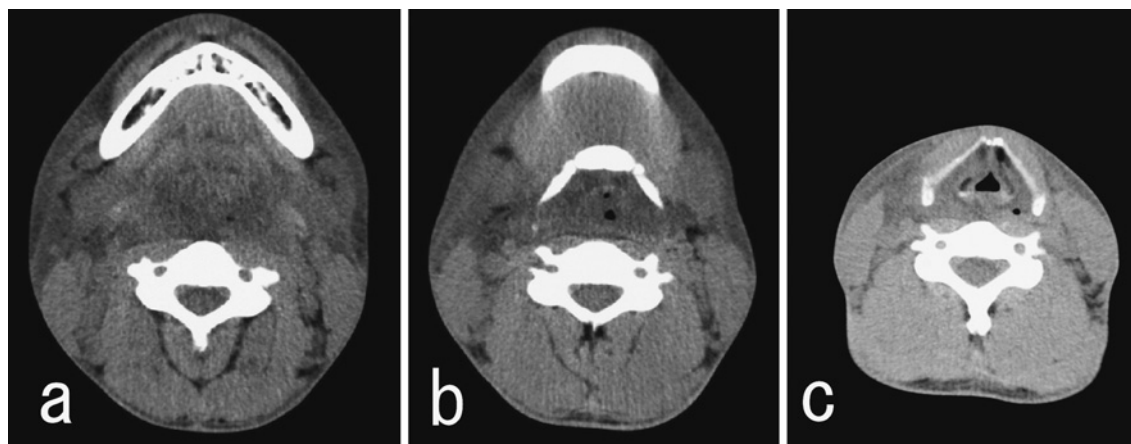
The postmortem neck CT showed diffusely increased density of the fat layer. Severe mucosal thickness with the effacement of the airway in the oropharynx (a) and the hypopharynx (b) was presented. The piriform recess (b) (c) and the laryngeal vallecula disappeared (b). Although, the fat density increased in the larynx, the glottis remained open (c).
